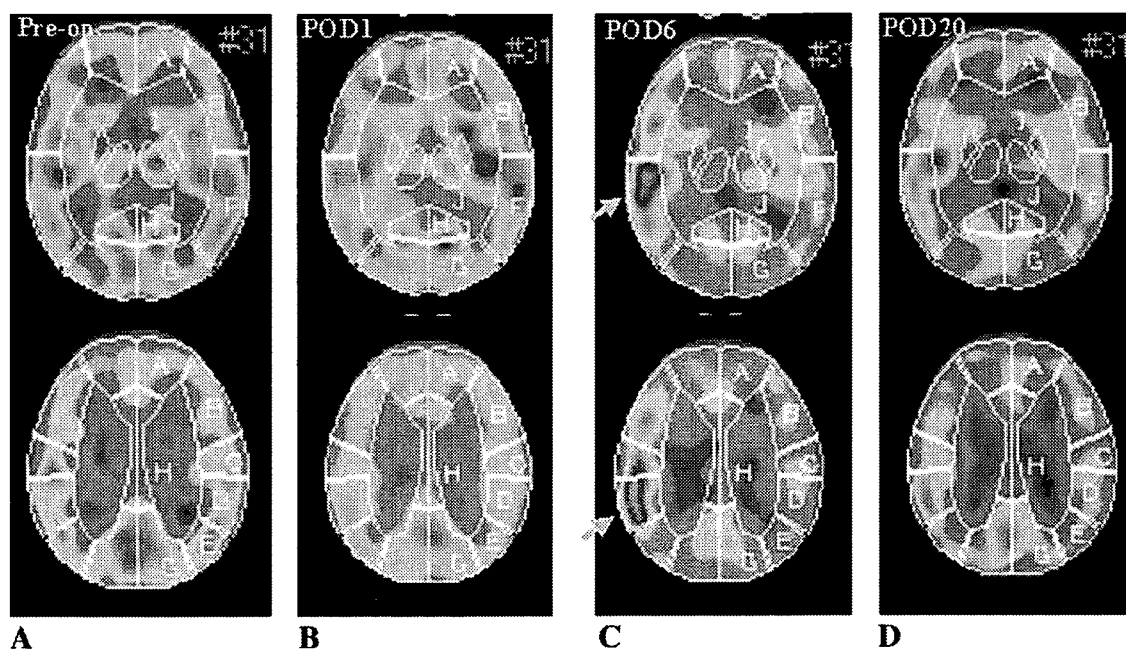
Case 1. ^{123}I -IMP-SPECT scans before surgery (A) and 1 (B), 6 (C), and 20 days (D) after surgery. The focal intense increase in CBF at the site of anastomosis (arrows in C) was evident as early as 6 days after surgery and preceded the manifestation of dysarthria and sensory disturbance on the left hand 7 days after surgery.
